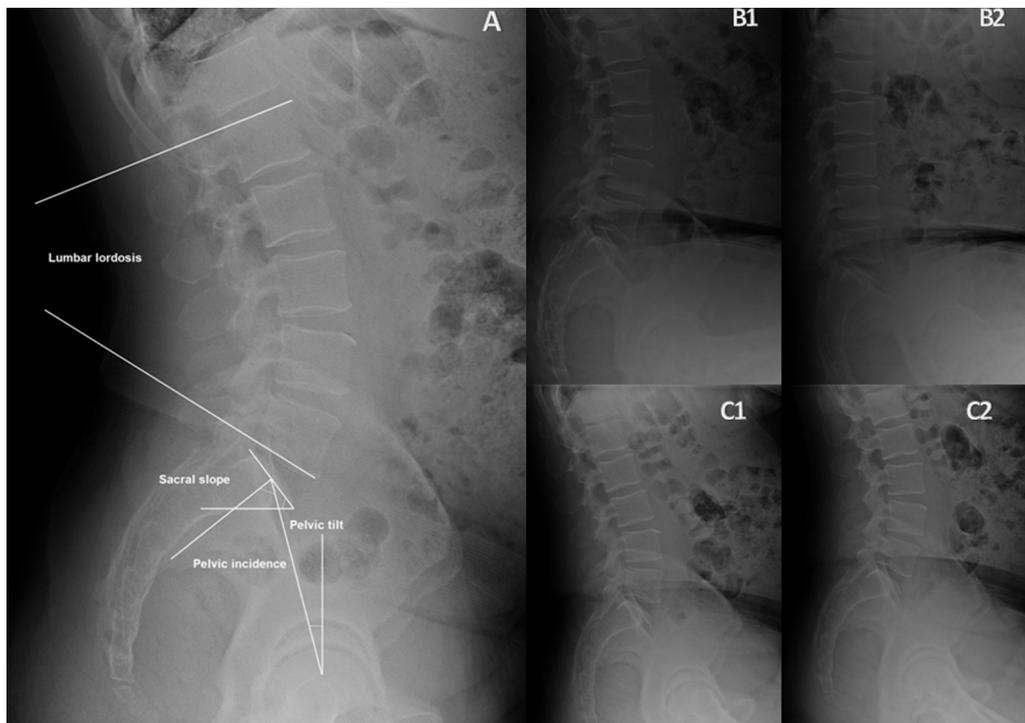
Radiographs taken under all conditions and variables measured described in Fig. 2A for conditions described in Fig. 1.
